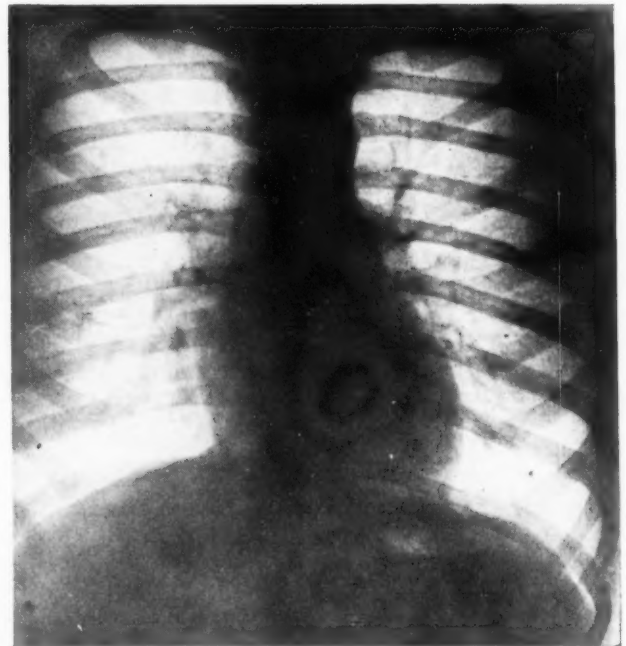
Chest x-ray of Anna S. showed calcified masses in the right lung and some tiny doughnut-like areas near the right cardiac border.
